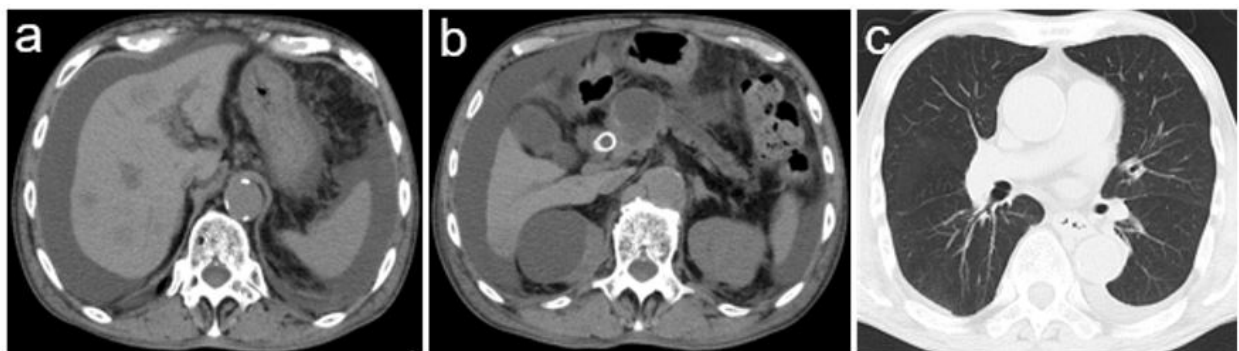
(a) Computed tomography (CT) shows liver metastasis. (b) CT shows pancreatic head cancer. (c) Lung CT scan shows no infiltration
